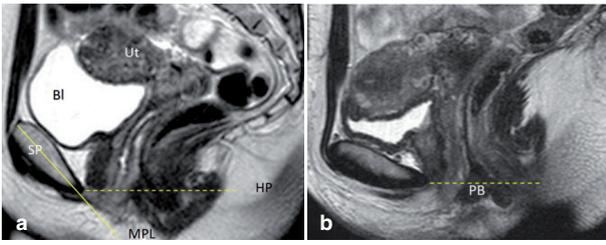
(a): Method for tracing the hymen plane on T2-weighted TSE midsagittal MR images of female pelvis (a): a line is drawn (dotted line) starting at the lowermost posterior point of the pubic bone through the external urethral and vaginal orifices. The midpubic line (continuous line) is depicted for comparison. (b): The hymen plane is used as reference to measure the position of the perineal body and the distal vaginal angle. BL= bladder; UT= uterus; SP= Symphysis Pubis; MPL= midpubic line; HP= Hymen plane.
